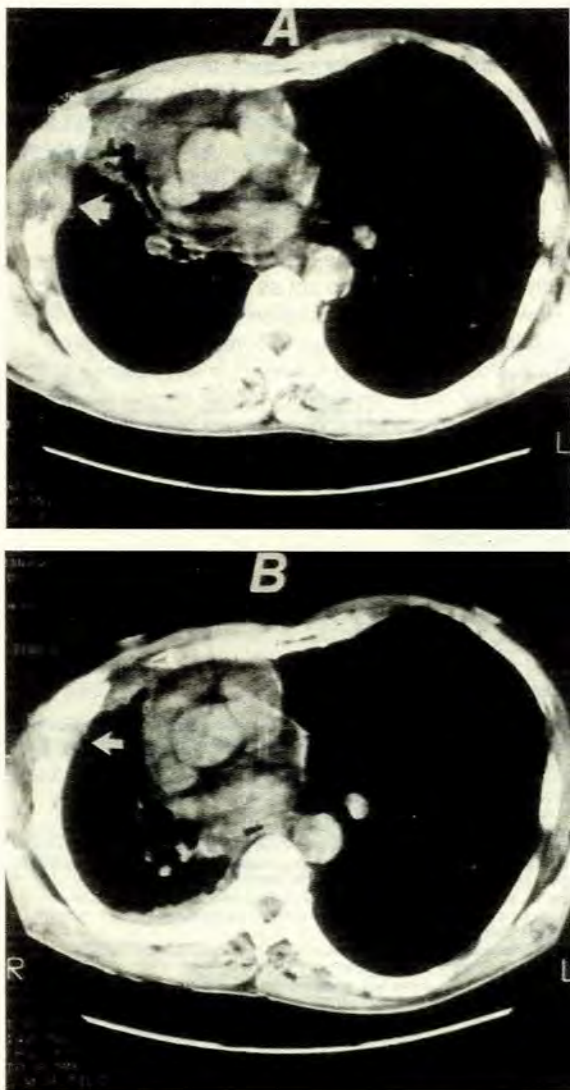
Chronological CT scans of the tumour in case 24 (Table I), at 2 months (A) and 29 months (B) after institution of hypoxoside therapy. Destruction of ribs 3 - 5 by adenocarcinoma (thick arrow) was reversed during therapy. Unique opacities were used as markers to select comparable scans.
